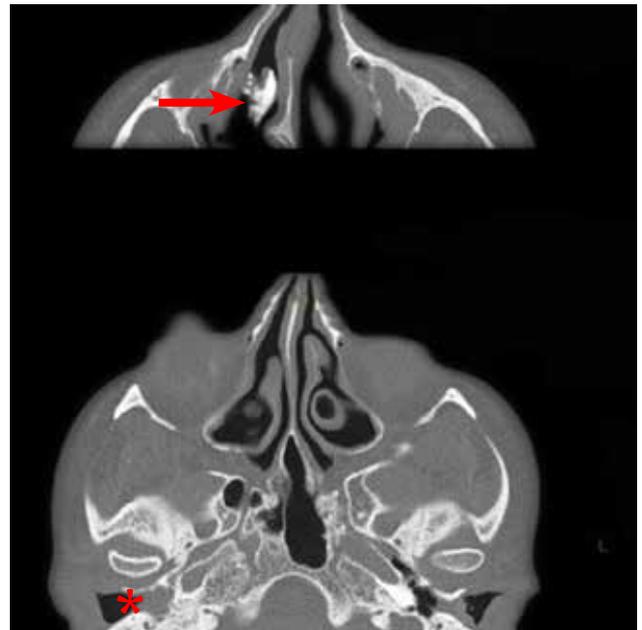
Coronal computed tomography showing a calcified space-consuming lesion occupying much of right nasal cavity with right maxillary sinusitis.
